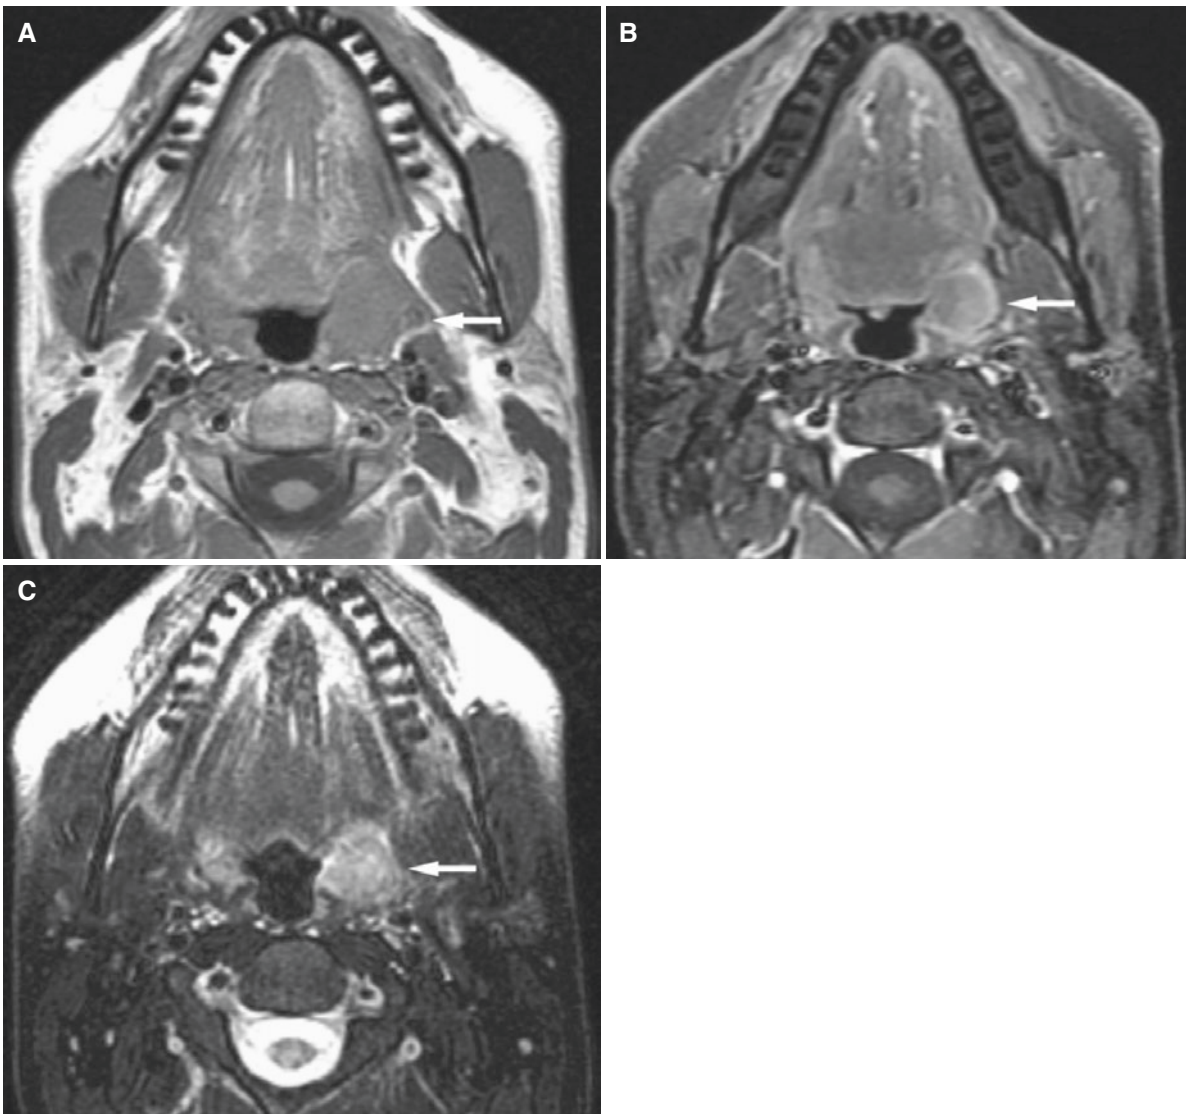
Squamous cell carcinoma of the tonsil; 43-year-old male with known multiple sclerosis and a history of squamous cell carcinoma of the left palatine tonsil. (A) Axial T1-weighted MRI shows low-to-intermediate-signal mass in the left palatine tonsil (*arrow*). (B) Axial
